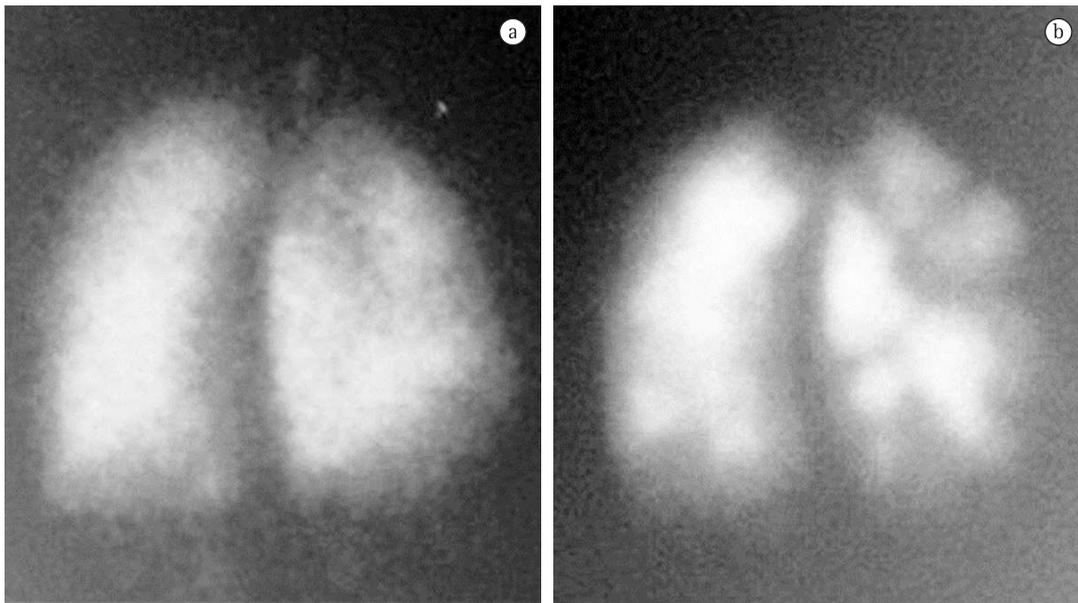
Ventilation/perfusion lung scintigraphy images of a 59-year-old male patient undergoing etiological investigation of pulmonary hypertension and with normal findings on CT angiography of the pulmonary arteries. Right posterior oblique images: ventilation (in a) and perfusion (in b). Note the normal distribution of ventilation and the multiple, bilateral segmental perfusion defects, predominantly in the right lung. The patient was diagnosed with distal, chronic pulmonary thromboembolism.
